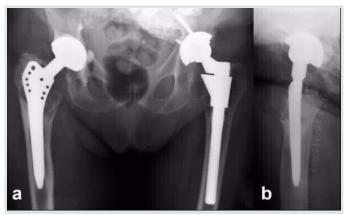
Postoperative X-ray: (a) Anteroposterior-view, (b) axial view.
